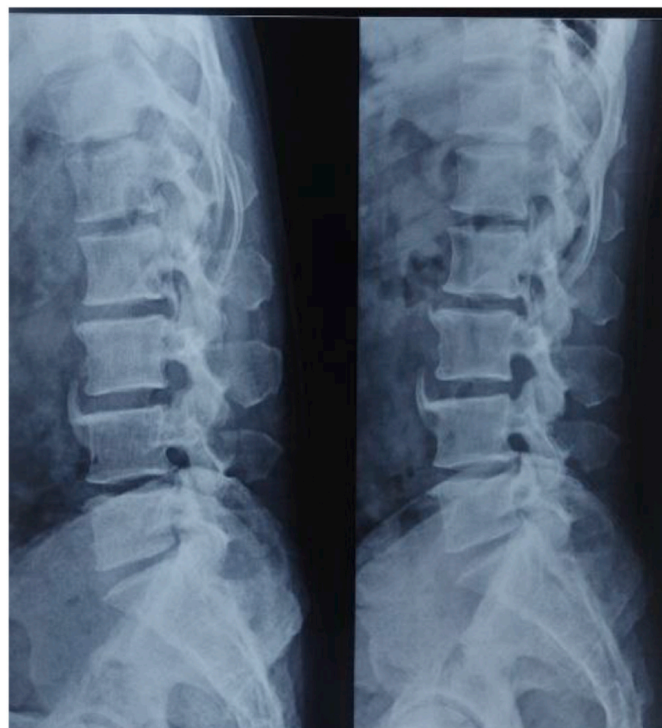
Preoperative X-ray showed calcified annulus at L1-2, L2-3 and L4-5 with anterior bridging osteophytes.
